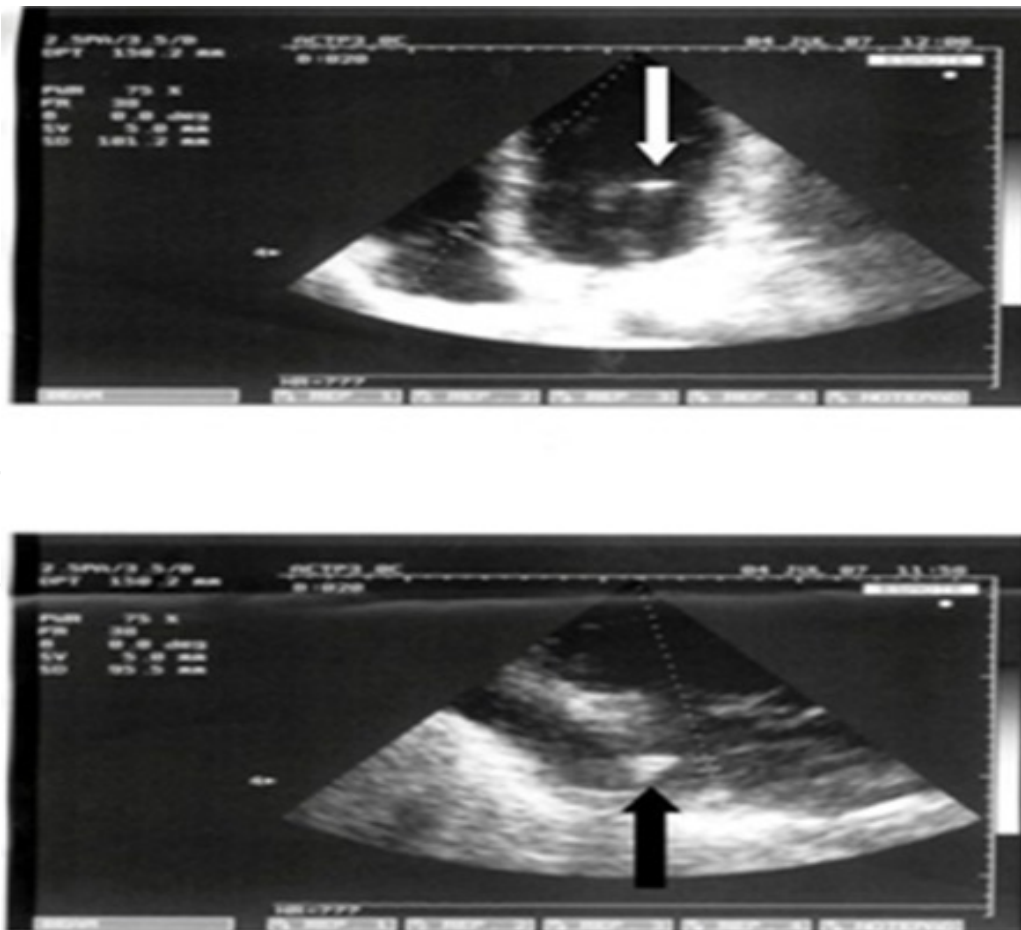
Cardiac ultrasound shows cysticercus in the cardiac muscle.
